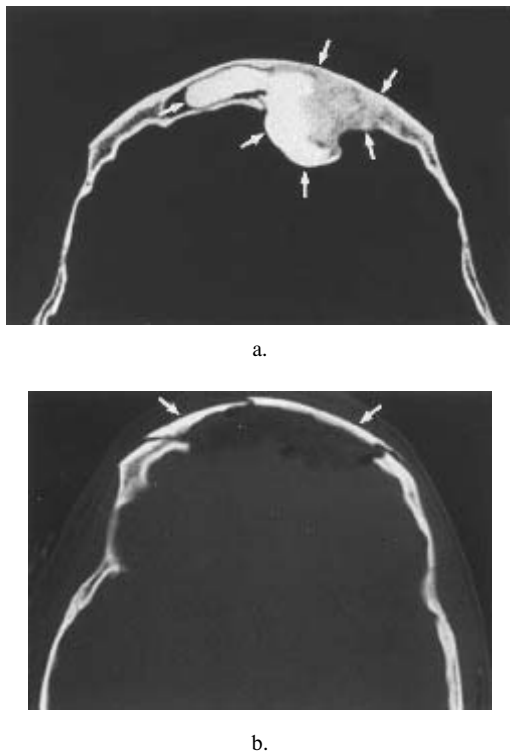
a, b. Huge frontal sinus osteoma affecting major parts of the anterior frontal sinus wall in a 21-years-old female patient (a). After coronal incision the osteoma was removed with the adjacent anterior frontal sinus wall. Reconstruction of the forehead region was accomplished harvesting an outer-table graft of the parietal region. Computed tomography (b) proves excellent aesthetic restoration.
